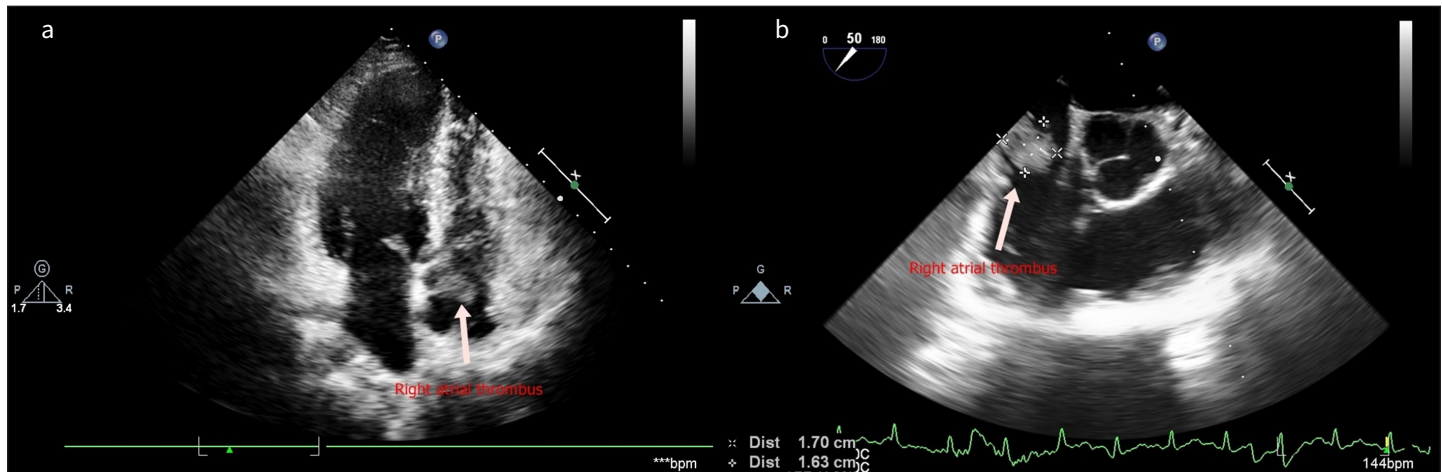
a, b. Transthoracic and transesophageal echocardiographic images of the right atrial thrombus.
